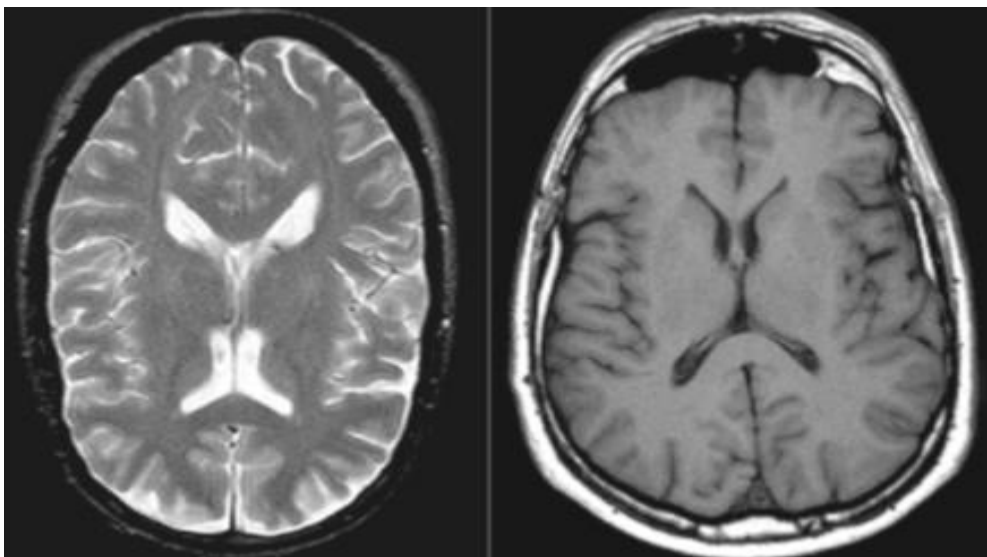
Shows T1 (on the right) and T2 weighted (on the left) MRI of the brain (Westbrook and Roth, 2011).
